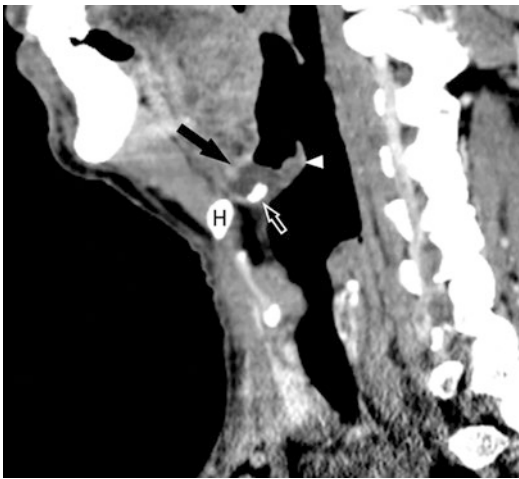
Laryngeal tuberculosis with abscess formation. This patient presented with cervical lymphadenopathy which turned out to be from metastatic poorly differentiated carcinoma of unknown origin. ENT examination showed a mass at the left side of the epiglottis. Biopsy of the epiglottic mass showed granuloma and the tissue was strongly positive for acid-fast bacilli. Sagittal contrast-enhanced CT image shows thickening of the epiglottis (arrowhead) with a rim-enhancing fluid collection at the epiglottic base extending to the vallecula (black solid arrow). A calcification within the abscess wall is present (small open arrow). H = hyoid bone
